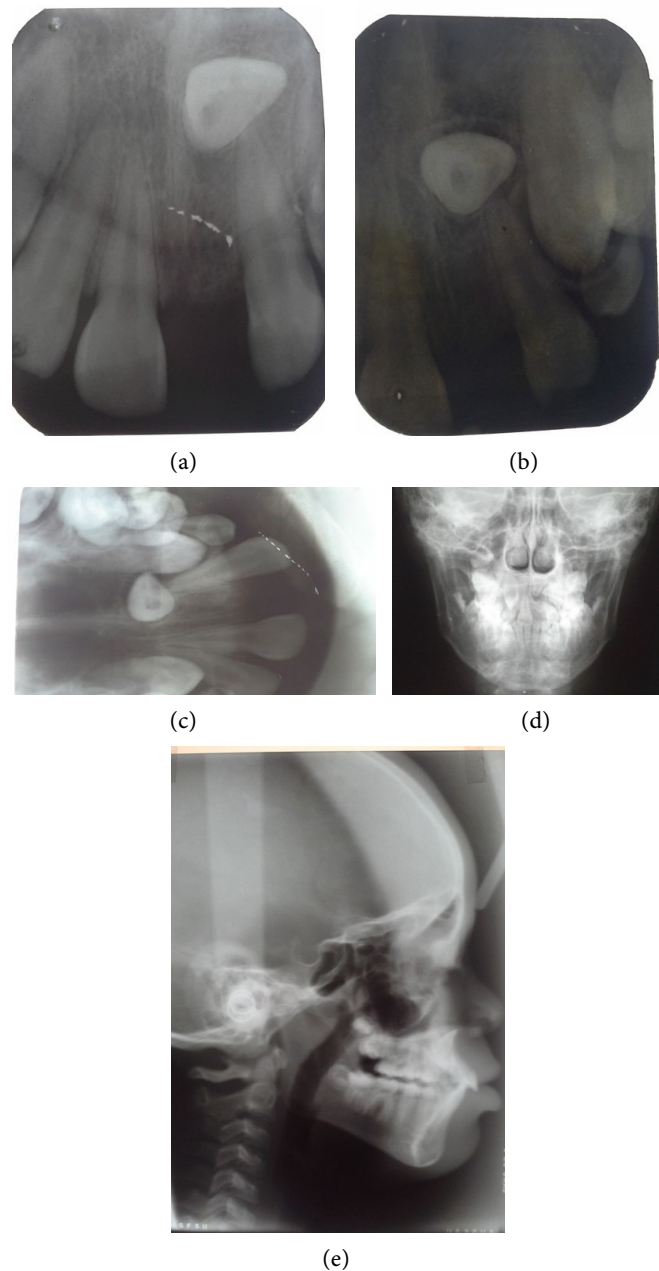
(a)-(b) Pre-treatment Periapical X-rays showing the parallax technique and a buccally placed tooth; (c) Upper occlusal X-ray showing the bull's eye appearance; (d) A view of the jaws; (e) Cephalometric X-ray.
